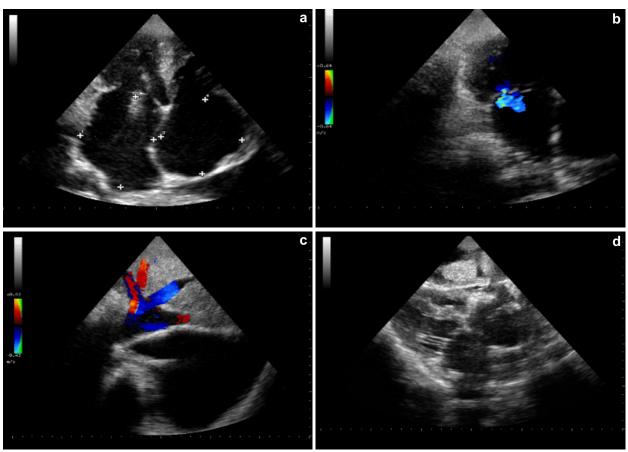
Two-dimensional (2D) echocardiographic examination revealed: (a) Dilated atria; (b) The presence of mitral valve regurgitation; (c) Suprahepatic vein stasis; (d) Small ventricles with hypertrophied walls and light granular and shinning ventricular myocardium.
